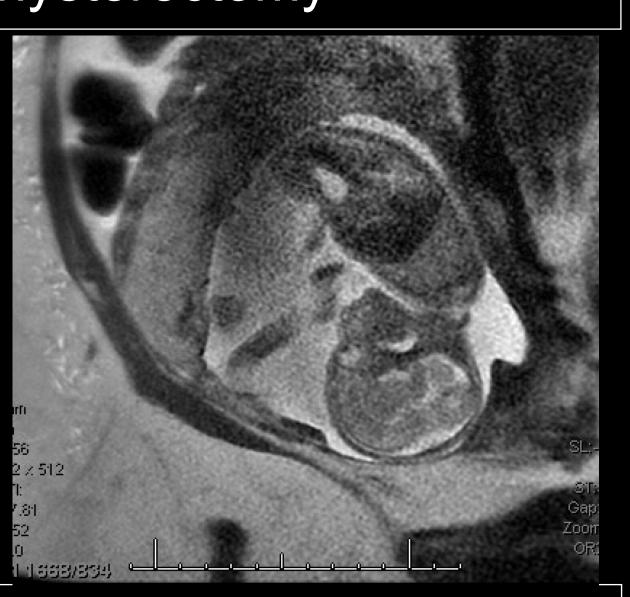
MRI showing ectopic pregnancy located at CS scar site and PAS placenta
